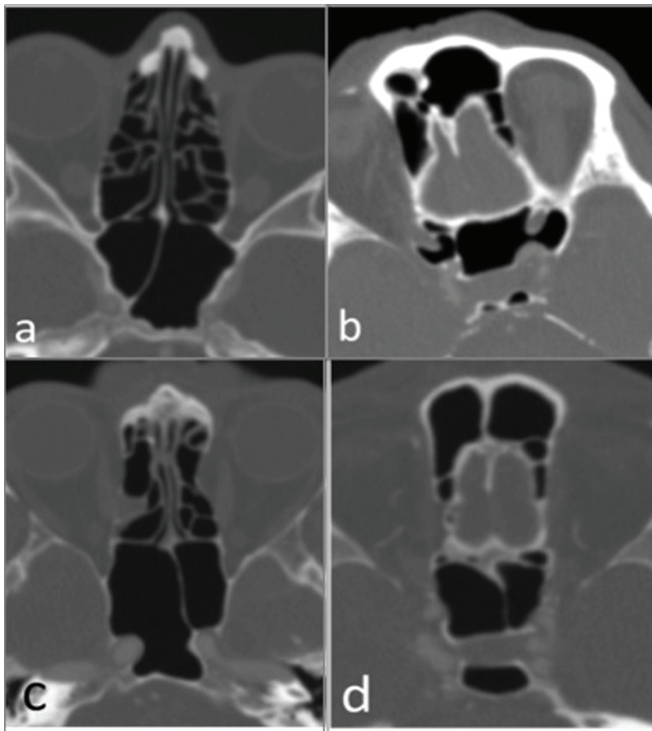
Deviation directions of main sphenoid septum. Axial computed tomography angiography (CTA) images obtained from the level of the ethmoid air cells (a) and pituitary gland (b) demonstrate the right deviation of the main sphenoid septum according to its posterior end point. Similarly, axial CTA images obtained from the same levels (c and d) show the left deviation of the main sphenoid septum according to its posterior end point. In (b and c), prominent protrusion of bilateral internal carotid arteries to sphenoid sinus is seen. Also note the prominent protrusion of bilateral optic nerves to sphenoid sinus in (b).
